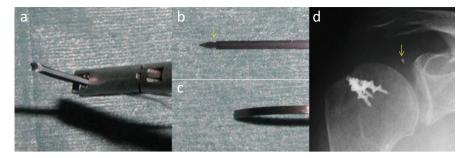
Breakage of suture passer needle tip. (a) Suture passer (Scorpion) is an implement for passing the thread through the rotator cuff. (b) The Scorpion needle before use. Breakage may occur at the constricted portion indicated by the *arrow*. (c) A needle lacking its tip, which was broken at the constricted portion of the needle. (d) X-ray image after arthroscopic rotator cuff repair. The broken needle tip was still in the rotator cuff
